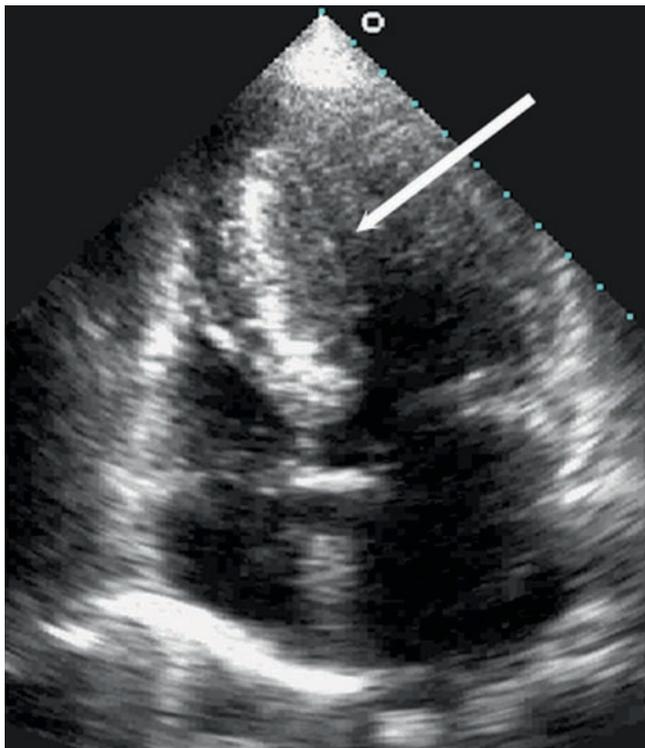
Apical four-chamber view of apical HCM with LV cavity obliteration in systole (apical arrow)
